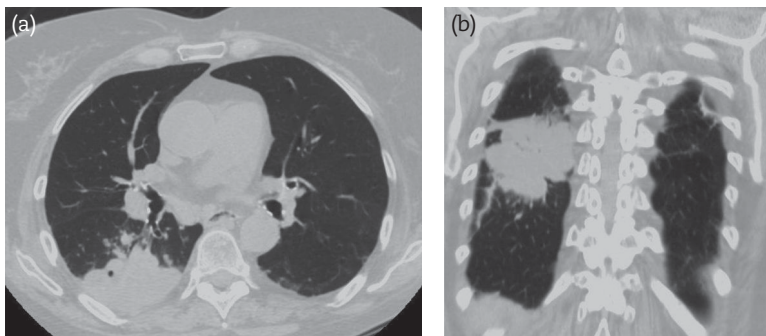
Computed tomography images of chest, axial and coronal views, right lower lobe mass.
